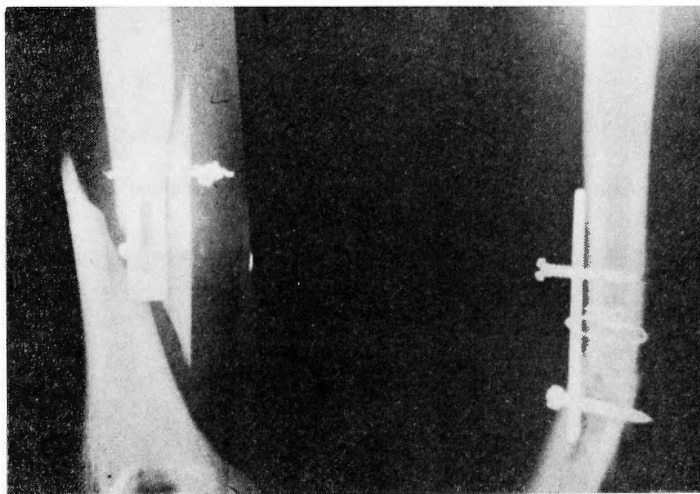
Case #3 Roentgenological finding of left humerus.
